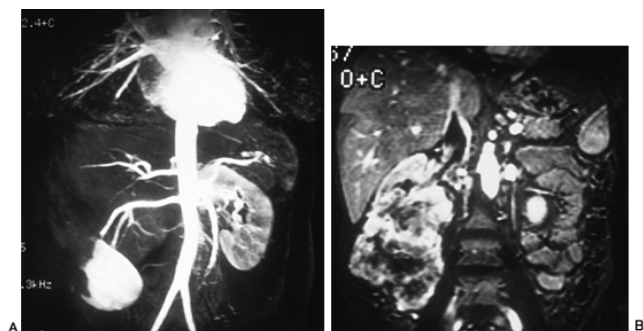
11. New methods of staging renal cancers with magnetic resonance imaging (MRI). A: Magnetic resonance angiogram (MRA) of a patient with a large right renal cancer demonstrates the elongation of the right renal artery and extrarenal branching of this vessel. B: Delayed MRA from another case demonstrates filling defect in the inferior vena cava arising from the right renal cancer. The absence of enhancement within the thrombus distally (bland thrombus) contrasts with the more proximal portion of the thrombus that shows enhancement.
